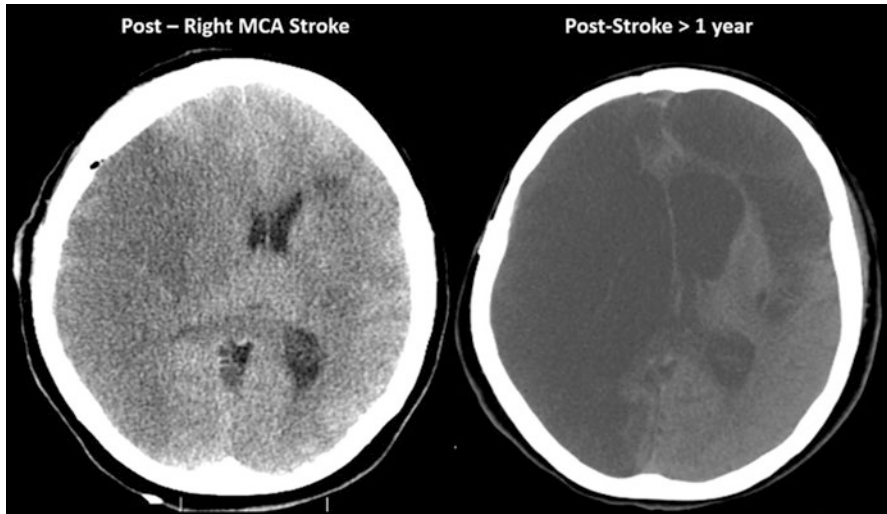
(Left) This patient experienced a rupture of a carotid artery aneurysm leading to a right middle cerebral artery (MCA) stroke. The CT on the left was performed at about 48 h post-incident and depicts the generalized infarction along the distribution of the entire right MCA with extensive brain edema and midline shift. (Right) More than 1 year post-injury, extensive regions of cystic formation as a consequence of the infarction along with a large secondary left frontal infarction, likely a result of the massive cerebral edema that occurred
